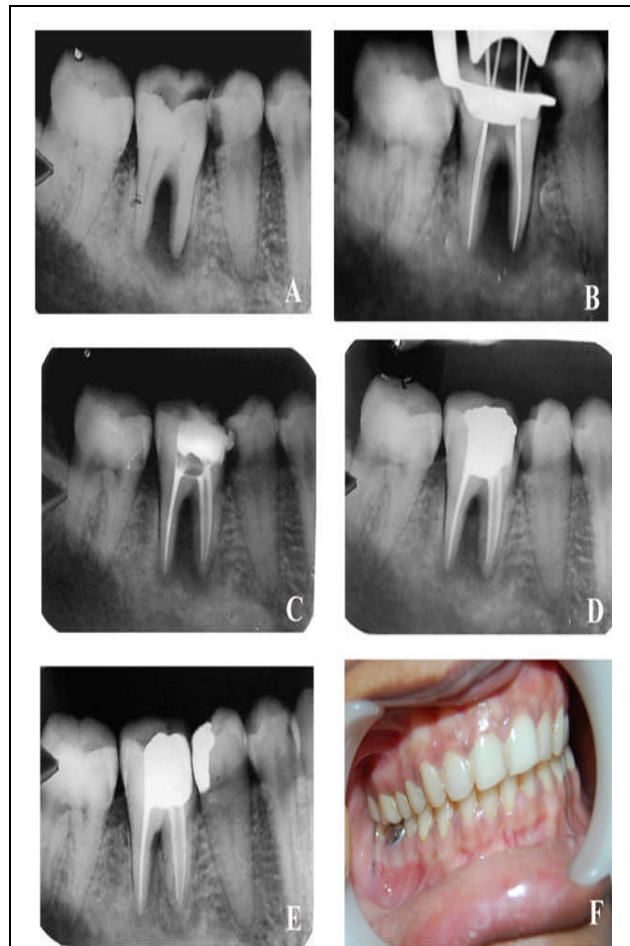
(A) Preoperative radiograph showing showed severe bone loss around the mesial portion of distal root, interradicular area and the apex of mesial root of tooth #30. (B) Working length radiograph of tooth #30 (C) Radiograph taken upon completion of root canal treatment. (D)Three month follow up showing periradicular tissues showed sign of regeneration (E) One year follow up radiograph showing evidence of bony healing (F) Clinically, no inflammation was seen on soft tissues and the tooth restored with full coverage metal crown.
